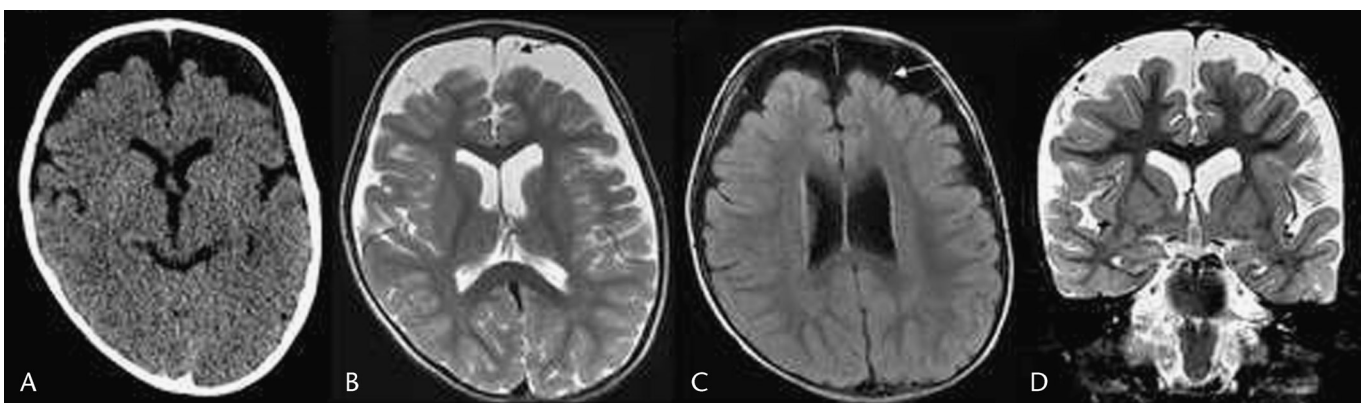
Benign extracerebral collections of infancy. A, Noncontrast computed tomographic images demonstrate normal brain densities with prominent frontal subarachnoid spaces bilaterally and slight widening of the ventricles and sylvian fissures. B–D, Magnetic resonance imaging in another infant. Axial T2 (B) and FLAIR (C) plus coronal short τ inversion recovery (D) images demonstrate linear cortical veins (arrows) traversing the enlarged extracerebral spaces that conform to CSF intensities on all sequences.
